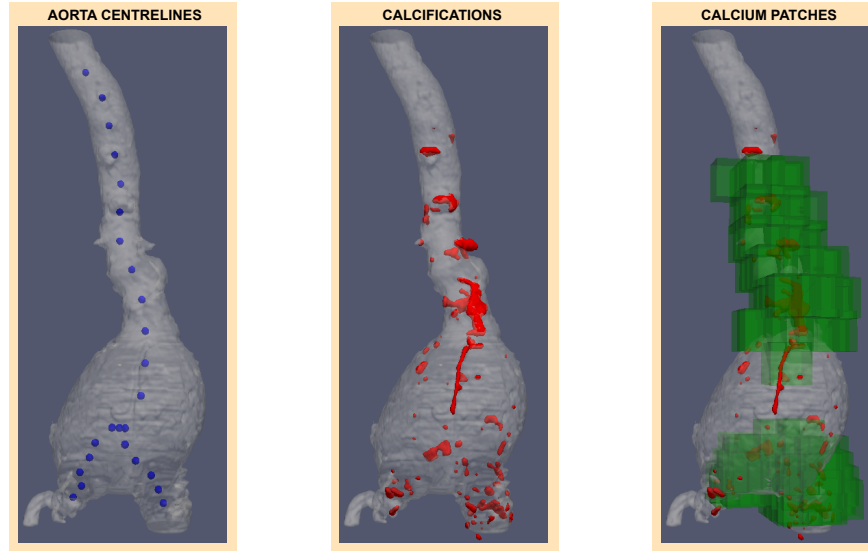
Automated selection of patches of calcium: patches of calcium (green boxes, right) are found using the centrelines of the aorta surface (left) and positions of the calcifications (centre) segmented from the CT scan.
